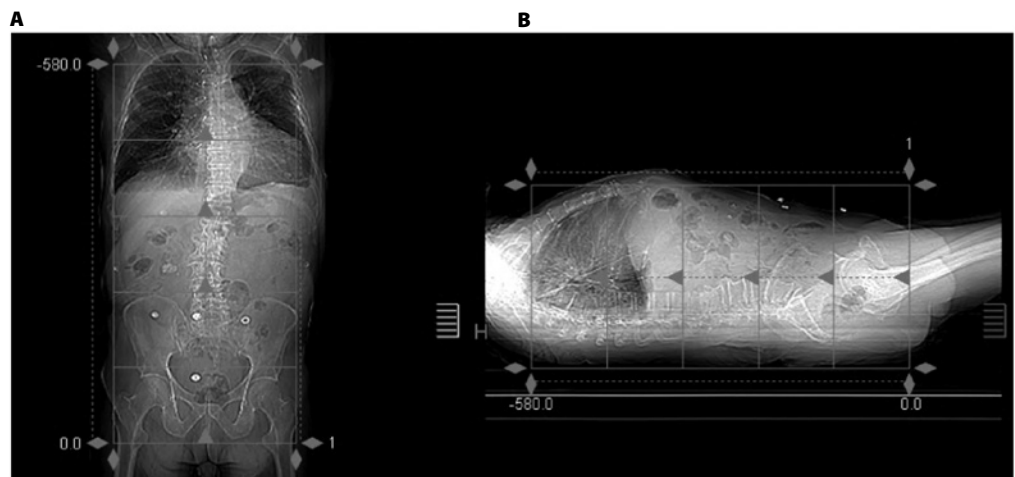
Anteroposterior (A) and lateral (B) topograms from the wide-area detector computed tomography system demonstrating the 16-cm volumes used for step-and-shoot axial imaging.
